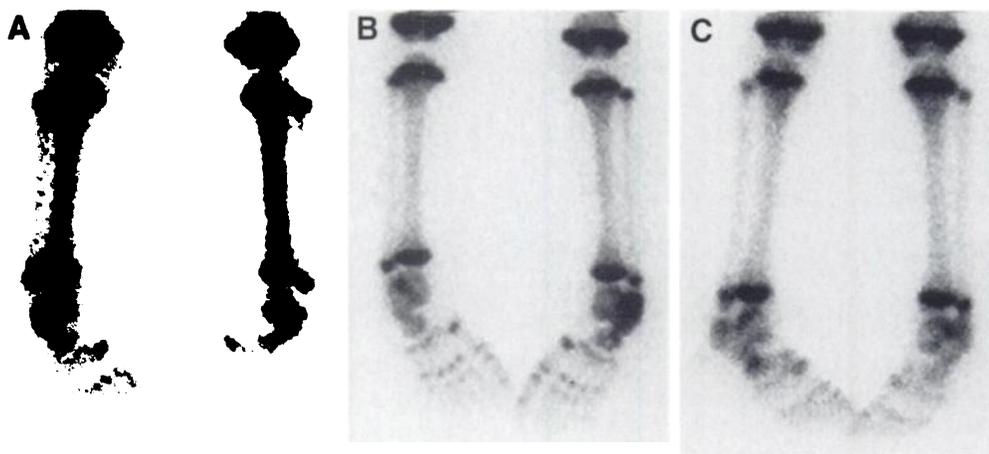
Injuries in toddlers. Skeletal scintigraphy shows increased tracer localization involving the left tibia (A), the left calcaneus (B) and the right cuboid (C) in three children 20–26 mo of age. Of note are the absence of tracer localization in the unossified tarsal naviculars and the prominent tracer localization in metatarsal and phalangeal ossification centers.
